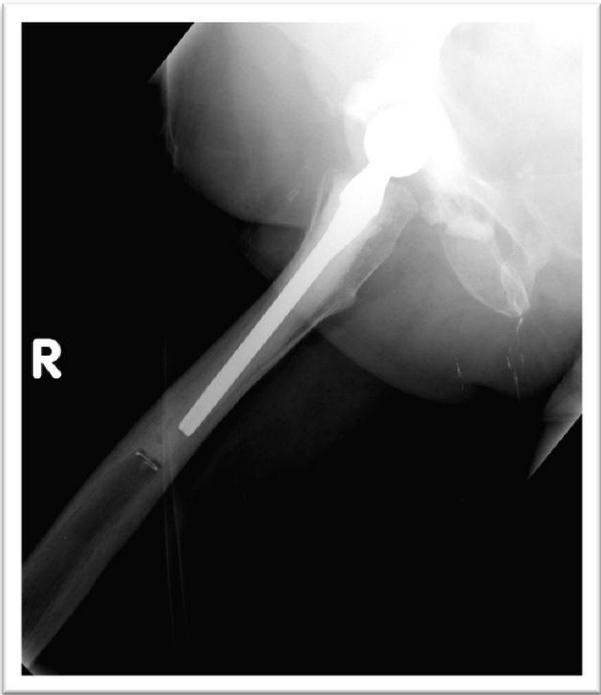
Standardised Iliac Oblique Radiograph
